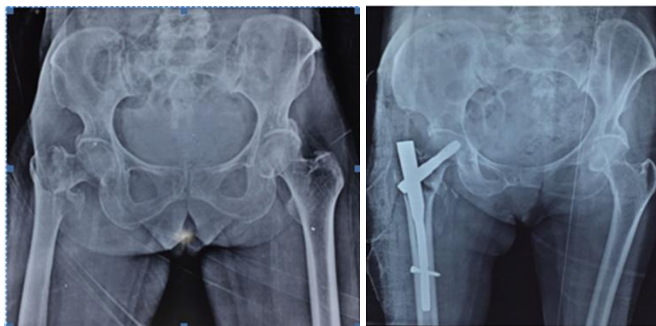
Preoperative and Postoperative x-rays of PFNA2 Fixation
